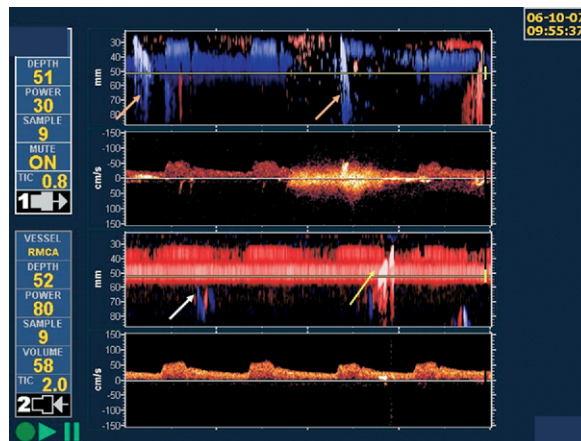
online only. Channel 1: Submandibular internal carotid artery (SICA) recording two microembolic signals (MES) (orange arrows). First one on the channel 2 power M-mode Doppler screen (recording middle and anterior cerebral artery [MCA + ACA]) traveled to ACA (white arrow). Second MES from SICA traveled to MCA (yellow arrow).
